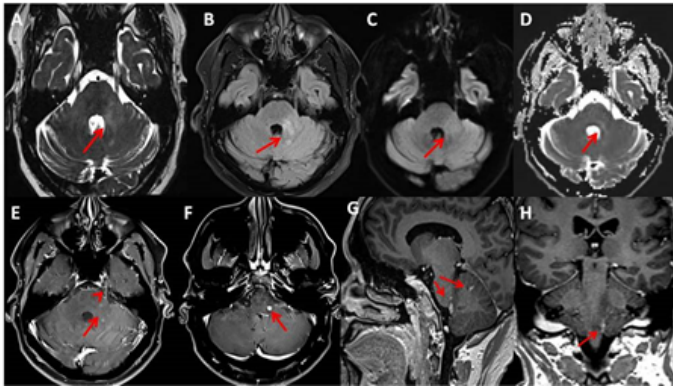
(2A & 2B) FIESTA and FLAIR axial section images through the brain show ill-defined patchy hyperintensities in the left middle cerebellar peduncle respectively (arrows). (2C & 2D) Axial section DWI and apparent diffusion coefficient images in the same section show no obvious diffusion restriction. (2E-2H) Axial, sagittal, and coronal post-contrast T1 weighted images through the brain show thickening and enhancement of the left trigeminal nerve (arrowhead), patchy areas of enhancing foci in the left middle cerebellar and inferior cerebellar peduncles with involvement of trigeminal nerve nucleus (arrows).
